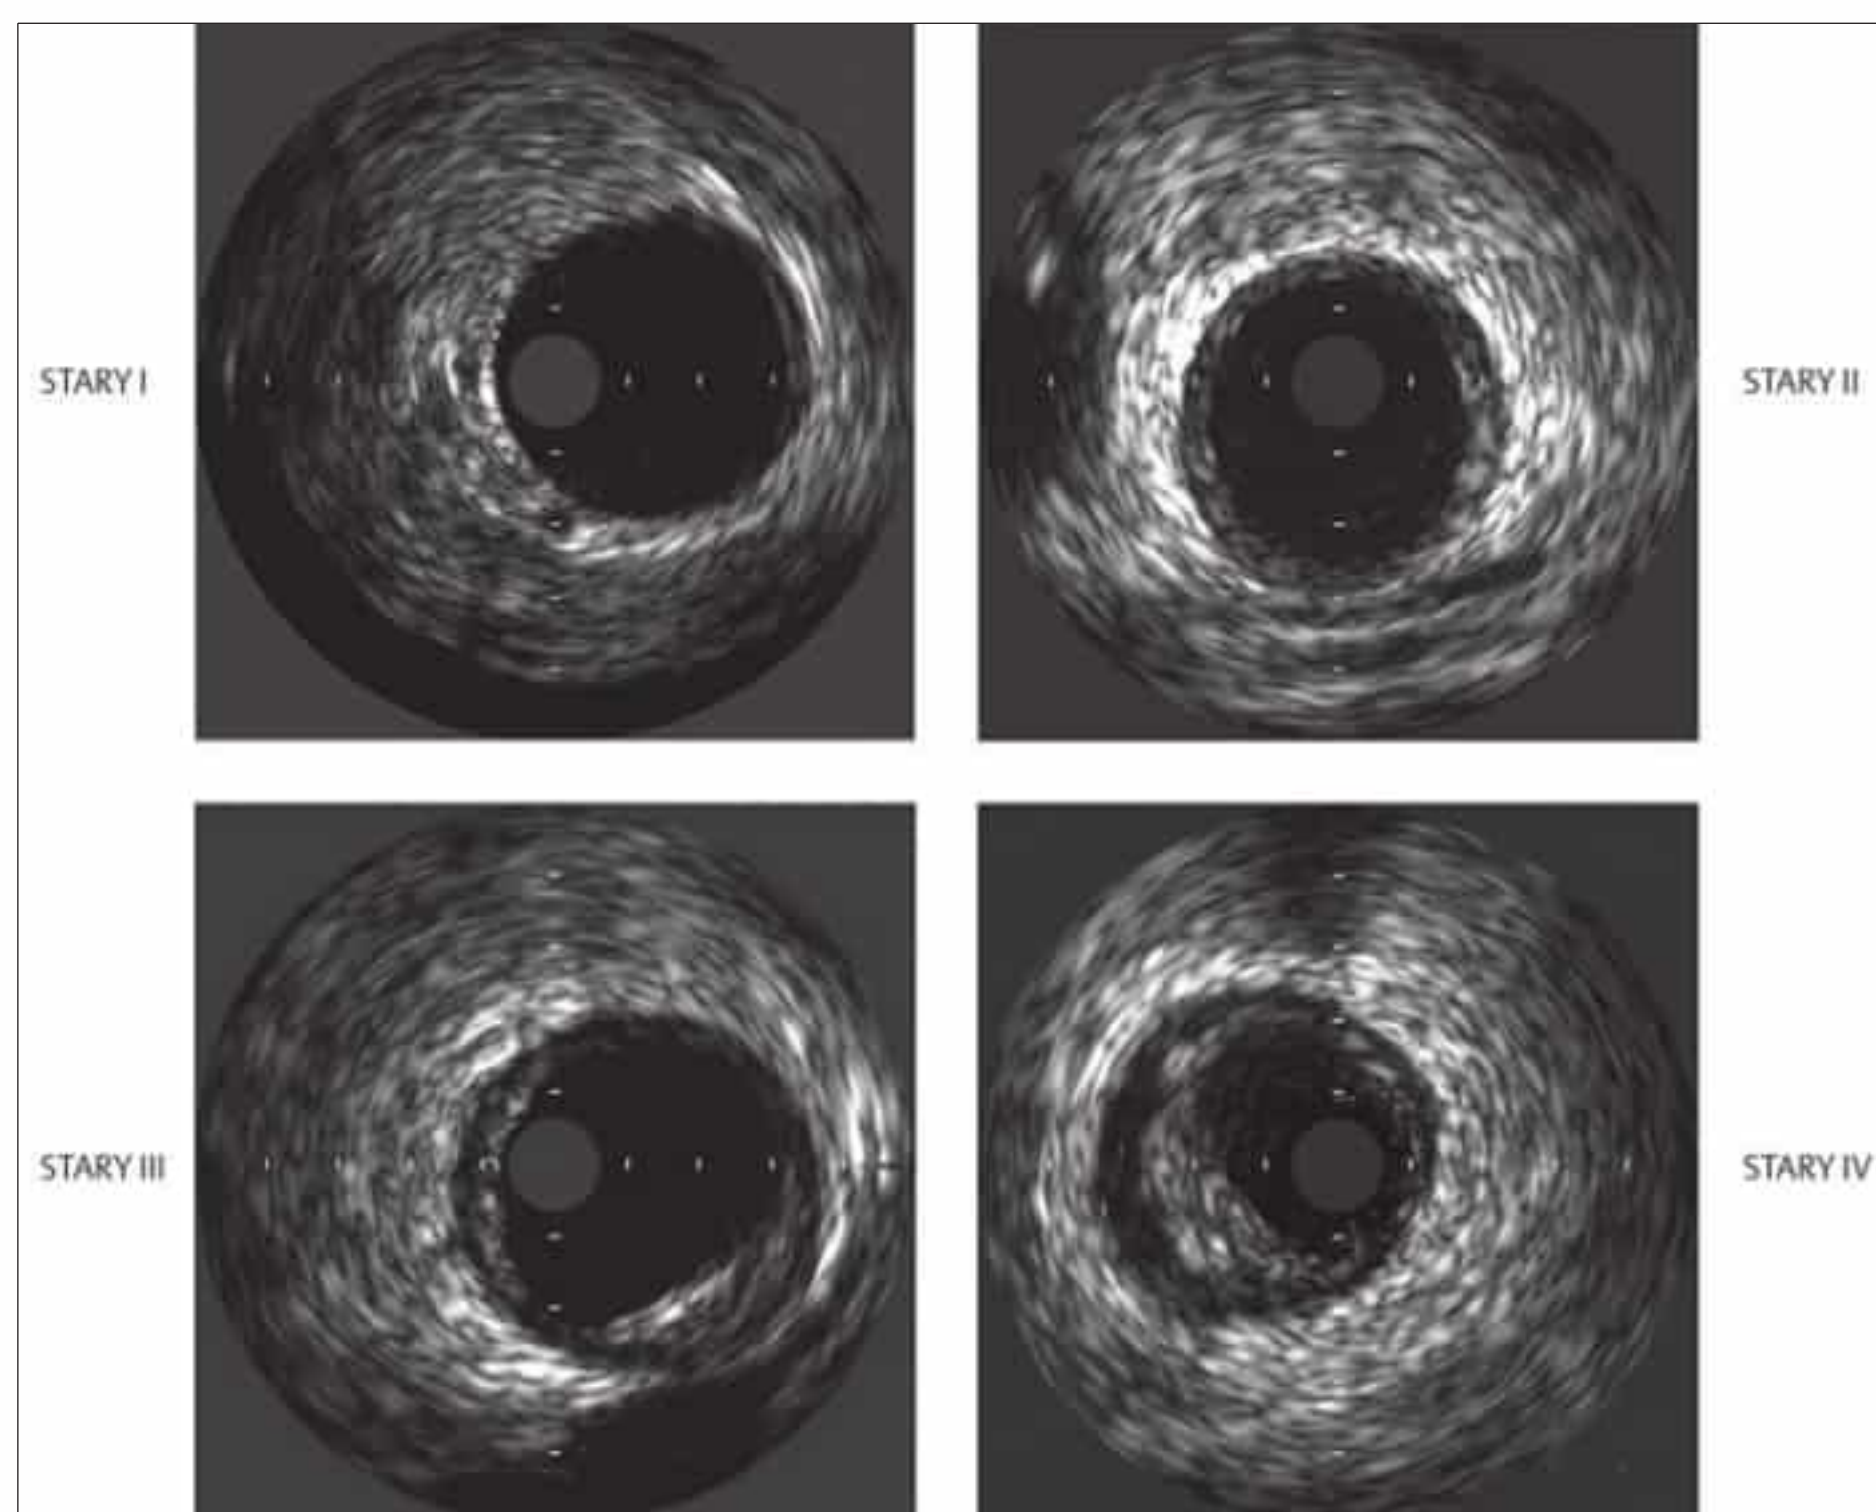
Intravascular ultrasound (IVUS). Images at Stary stages I, II, III, and IV show intimal thickening in stage II, localized eccentric plaque formation in stage III, and eccentric plaque formation with hypoechoic lipid deposits in stage IV (after Erbel 1996¹³).
